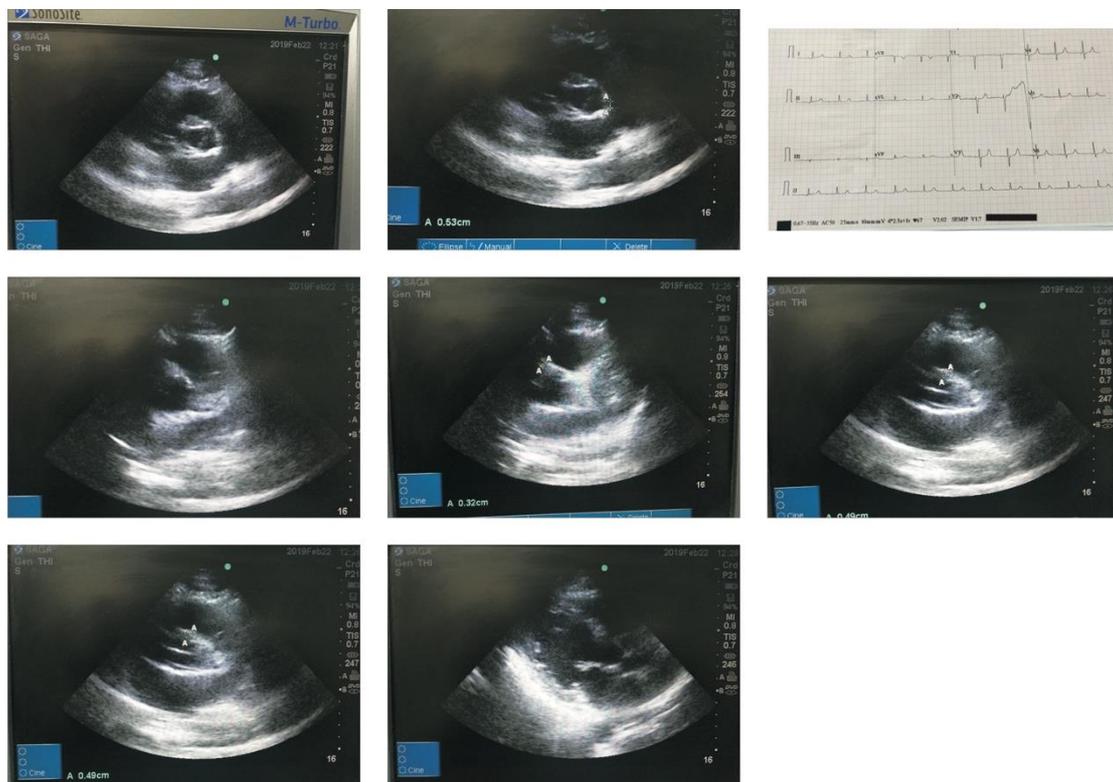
The echocardiography in a patient with peripheral arteriovenous fistula on dialysis for chronic renal failure. The left ventricular dimensions are normal without hypertrophy and coronaries are dilated.
